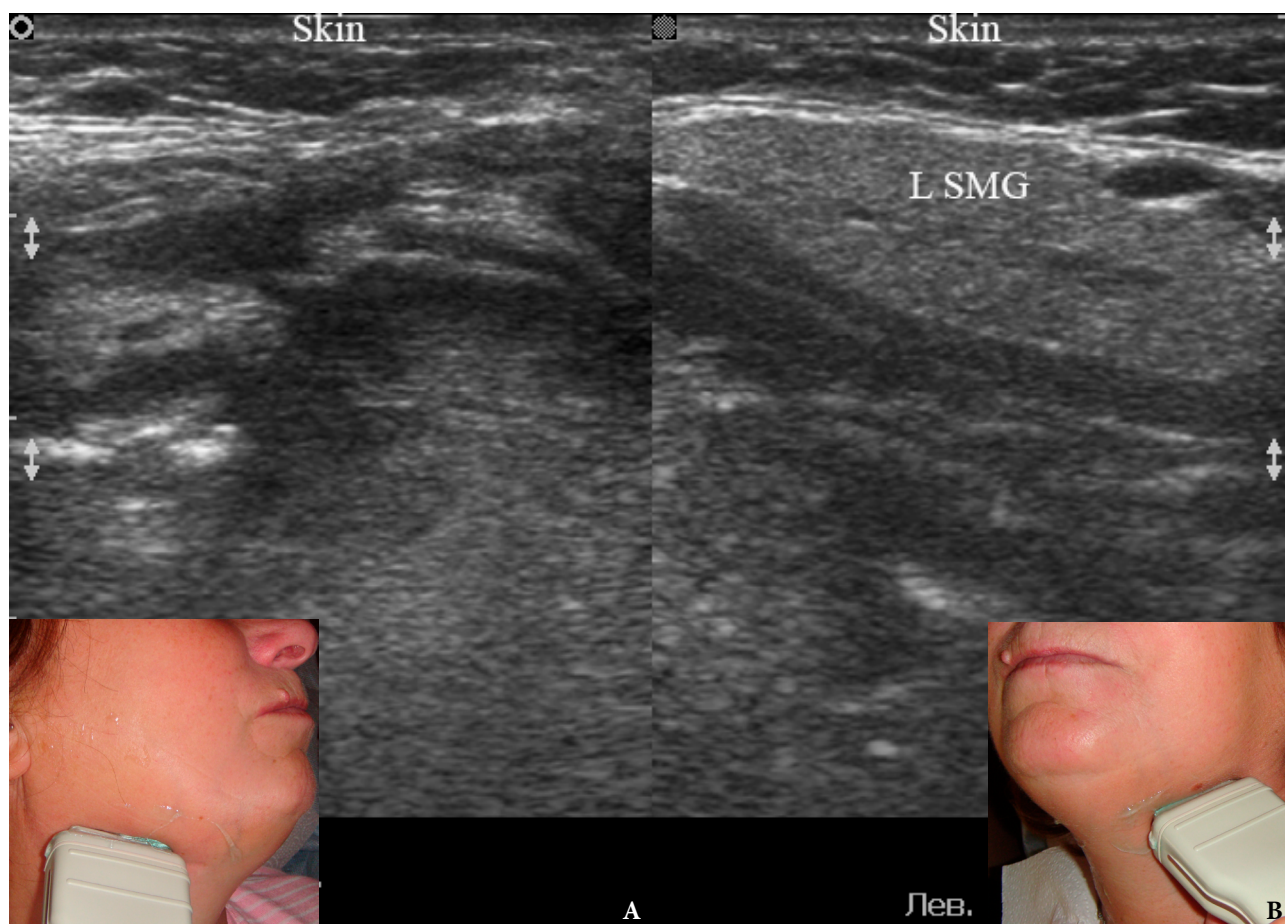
Comparison of gray scale sonograms of the right (A) and left (B) submandibular areas on the day 6 from the moment of the patient's hospitalization and on the day 3 from the moment of the sialolith removal. The absence of the right submandibular gland and the presence of an unchanged left submandibular gland (L SMG) are noted. The “depth” of ultrasonography is 4.0 cm.
